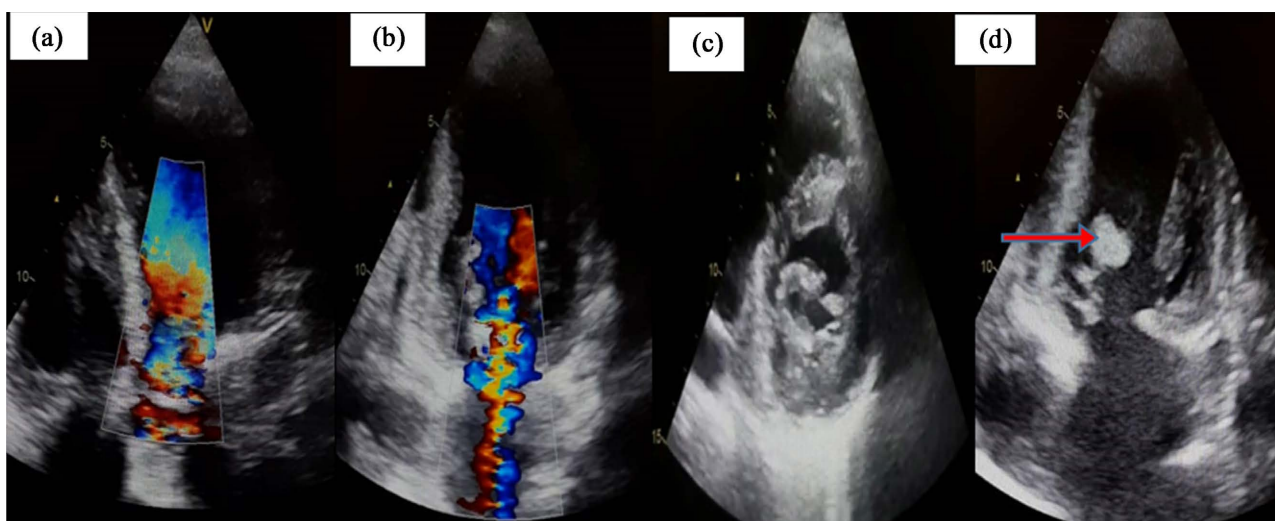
Resting transthoracic echocardiography images: (a) Apical 5-chamber two-dimensional section coupled with color Doppler showing aortic regurgitation; (b) Apical 2-chamber two-dimensional slice coupled to color Doppler showing mitral regurgitation; (c) two-dimensional parasternal trans mitral short axis section showing a remodeled calcified mitral valve; (d) Apical 2-cavity two-dimensional section showing the vegetation on the large mitral valve (red arrow).
